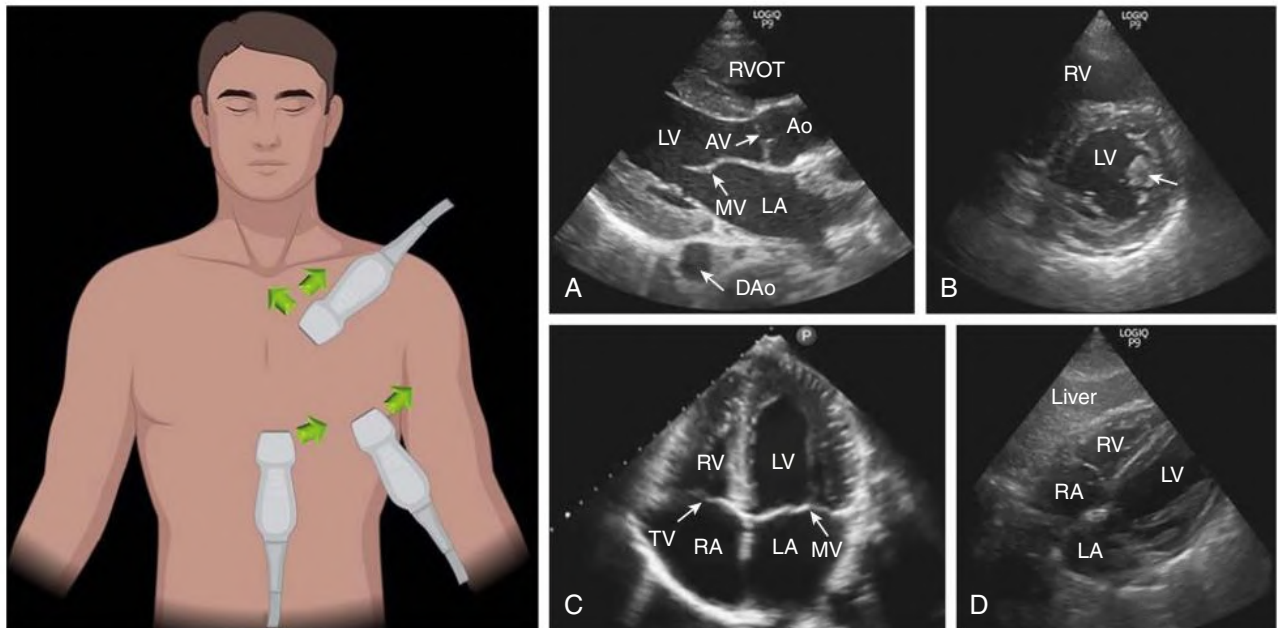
Standard Views of Focused Cardiac Ultrasound. *Left*, Transducer position to acquire these views. *Green arrows* denote direction of the transducer orientation marker. *Right*, Sonographic images of parasternal long axis (A), parasternal short axis (B; *arrow* indicates papillary muscle), and apical (C) and subcostal (D) four-chamber views. *Ao*, Aorta; *AV*, aortic valve; *DAo*, descending thoracic aorta; *LA*, left atrium; *LV*, left ventricle; *MV*, mitral valve; *RA*, right atrium; *RV*, right ventricle; *RVOT*, right ventricular outflow tract; *TV*, tricuspid valve. (Created with [Biorender.com](https://www.biorender.com).)
